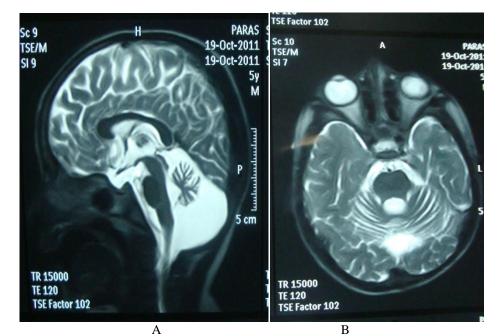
Sagittal (A) and coronal (B) magnetic resonance imaging showing severely reduced cerebellar volume in T2-weighted sequences at the age of 5 years.
